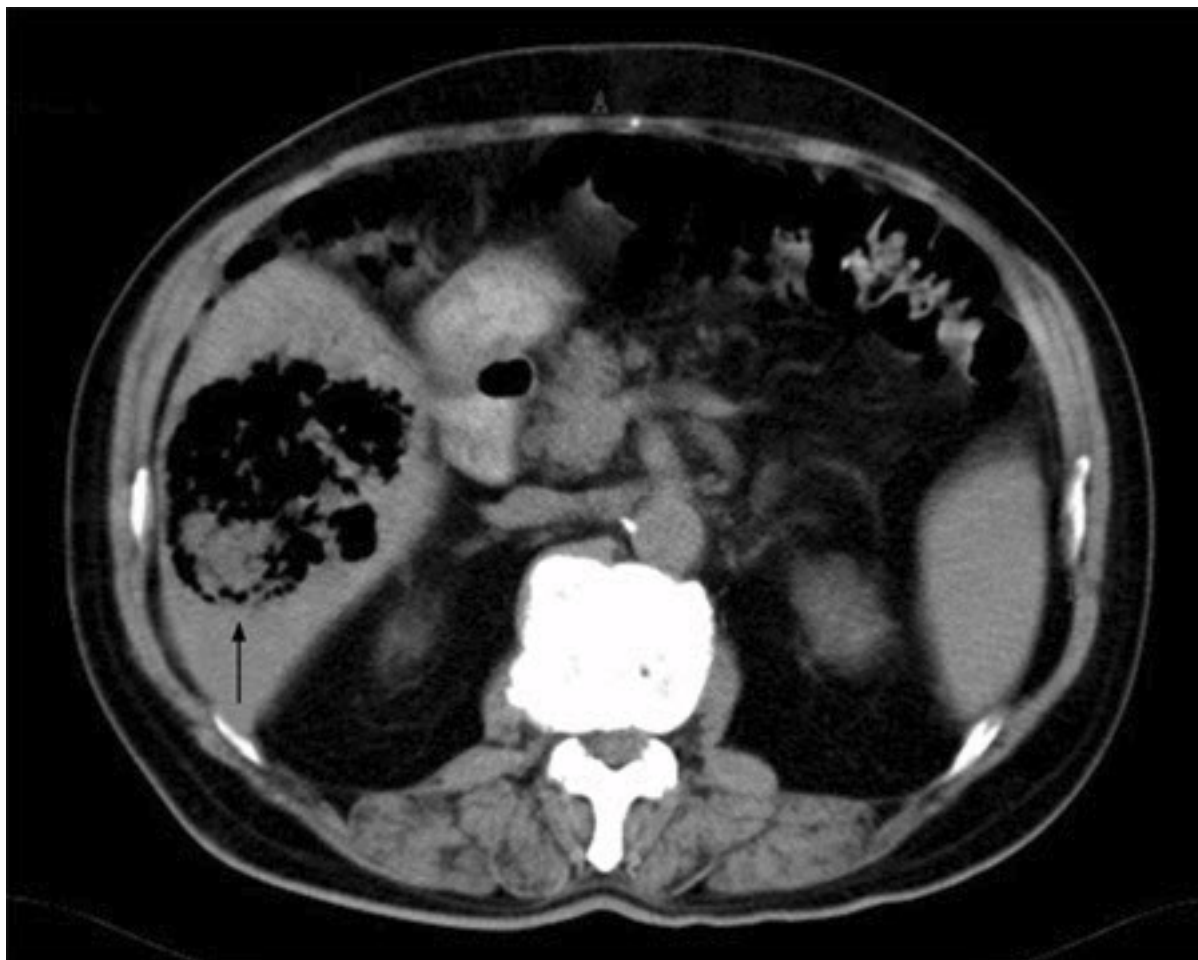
Liver abscess: A non-contrast abdominal CT scan showing a huge gas-containing liver abscess (arrow)
